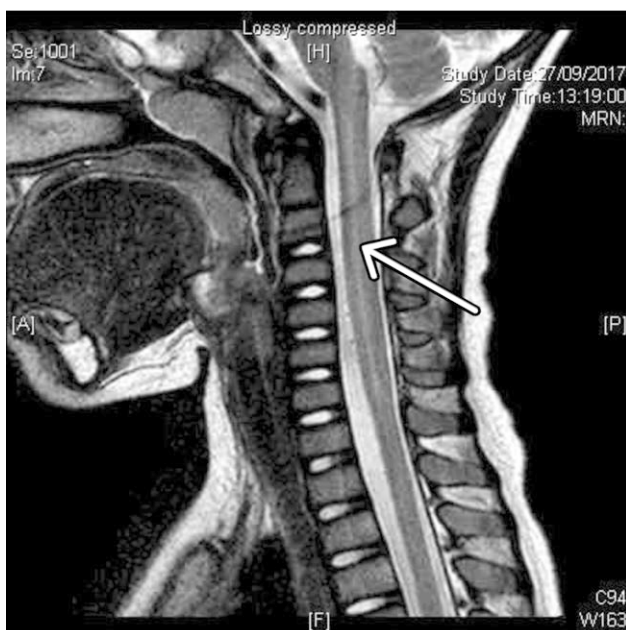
MRI spine showing long segment of T2W hyperintense signal at the cervical spinal cord (arrow).
